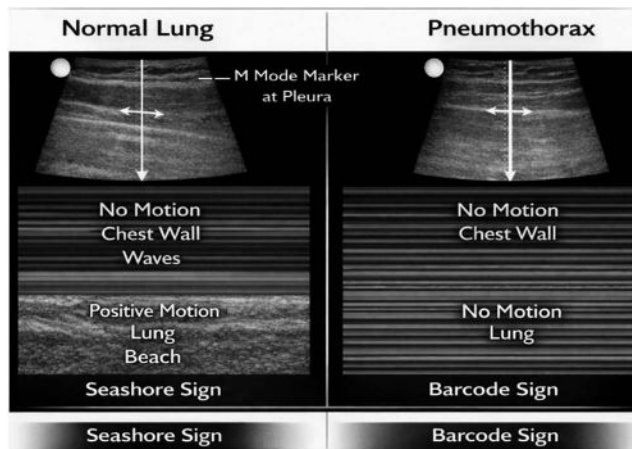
Ultrasound image of the lung for point-of-care ultrasound (POCUS) examination using a linear probe. On the left, the “seashore sign” is demonstrated, in which the chest wall is represented by horizontal lines, and the lung parenchyma is grainy, indicating movement of the lung parenchyma. On the right, the image consists entirely of horizontal lines, indicating no movement of the lung parenchyma (figure courtesy of Serpil Ozgen).
